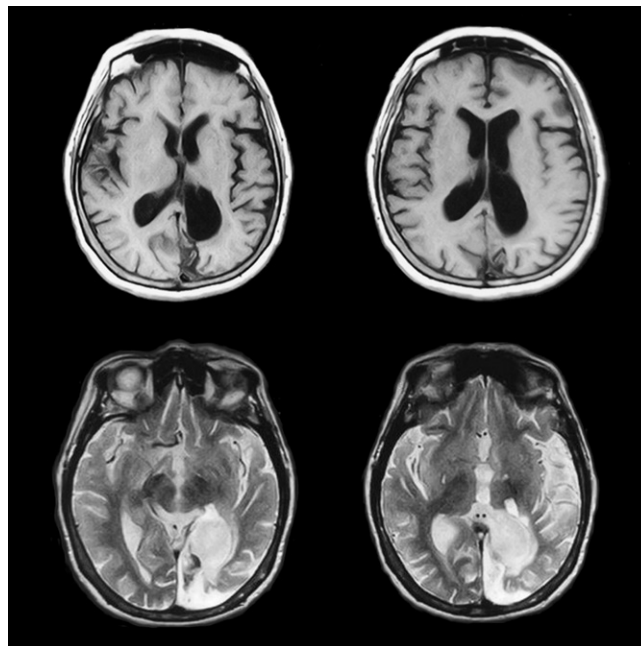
Magnetic resonance images.
